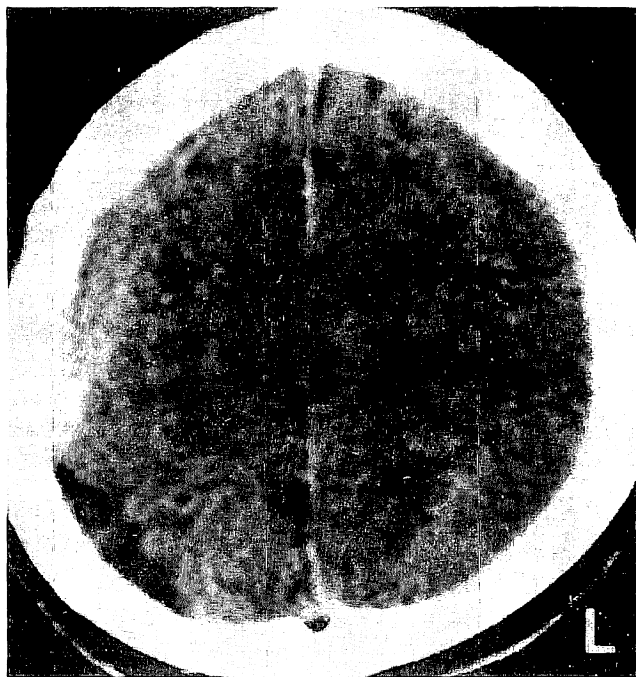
Computed tomography on day 30 shows the bilateral chronic subdural hematoma. This was drained by means of a burr hole procedure.
